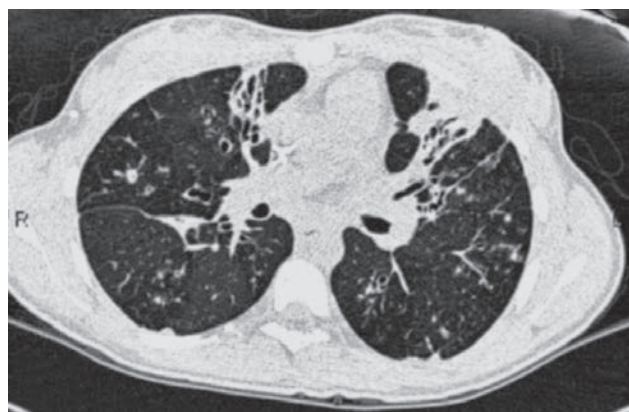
Computed tomography scan showing severe bilateral bronchiectasis
